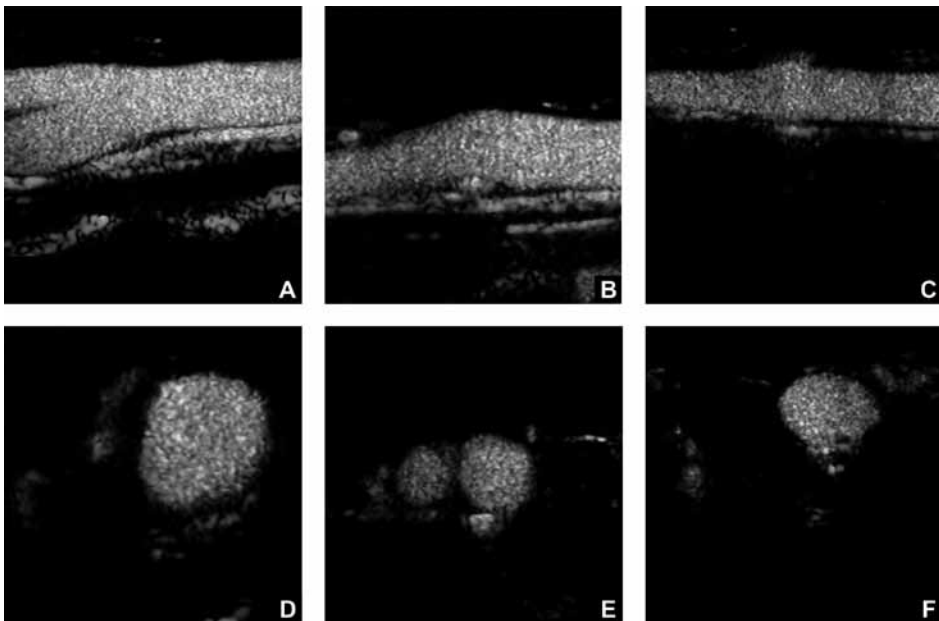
Longitudinal (Panel A-C) and transverse (Panel D-F) contrast enhanced ultrasound images of 3 patients. In all patients pseudoenhancement can be observed parallel to the main lumen.
